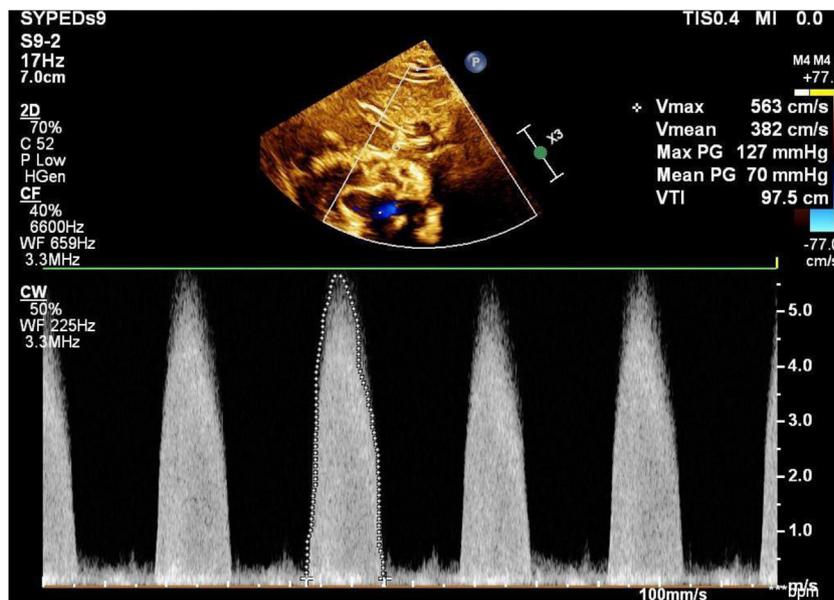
Two-dimensional TTE, suprasternal notch view with color-guided continuous-wave spectral Doppler interrogation of the ascending aorta confirms a high-velocity jet of 5.63 m/sec corresponding to a peak gradient of 127 mm Hg.
